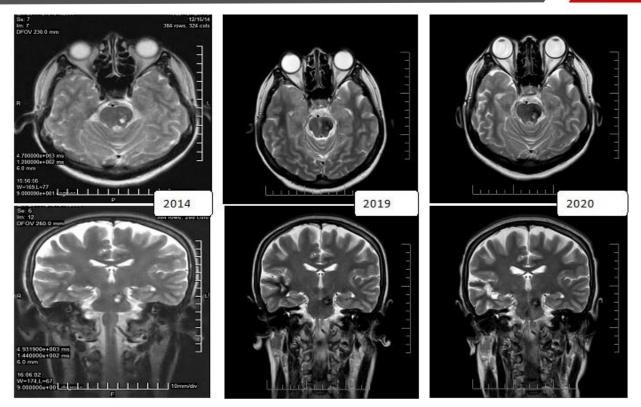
MRI of the brain T2, axial and coronary scans, in dynamics over 6 years (there are no data for hemorrhages of the CM of the brainstem).
